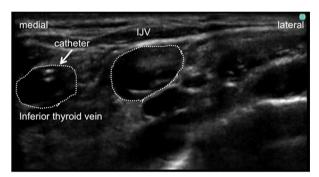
Ultrasound image of the right supraclavicular fossa.
